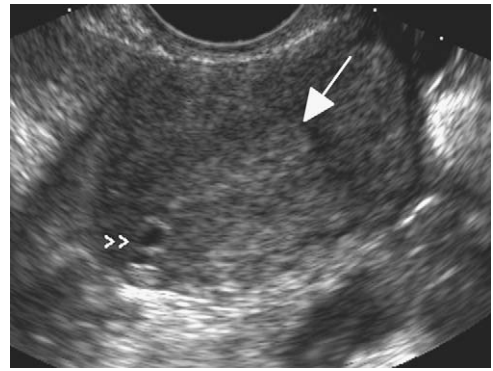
Interstitial line sign. Transvaginal ultrasound of the uterus shows no evidence of a normal intrauterine pregnancy. The 2 layers of the echogenic endometrium are coapted (arrow) and extend to the center of a small round fluid collection (arrowheads) eccentrically located in the myometrium.
